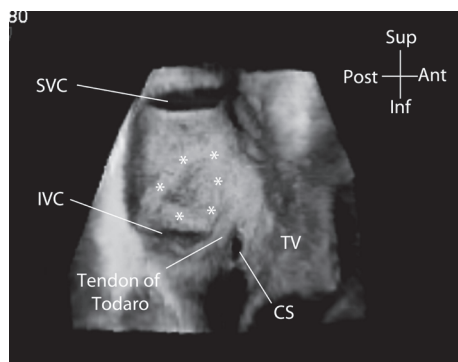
Normal atrial septum. Transoesophageal 3DE view of the normal atrial septum viewed from the right atrial aspect. The orientation of the image is anatomic so the superior vena cava and inferior vena cava are shown uppermost and lowermost on the image respectively. This image was acquired by 3D TOE using a full-volume acquisition over 4 cardiac cycles. The asterisk marks the margins of the oval fossa. SVC, superior vena cava; IVC, inferior vena cava; TV, tricuspid valve; CS, coronary sinus.
